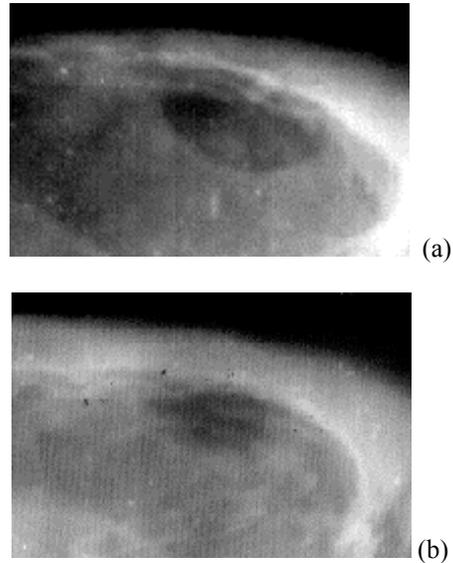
The radiograph of the implant after operation (a) and five mounts later (b)
